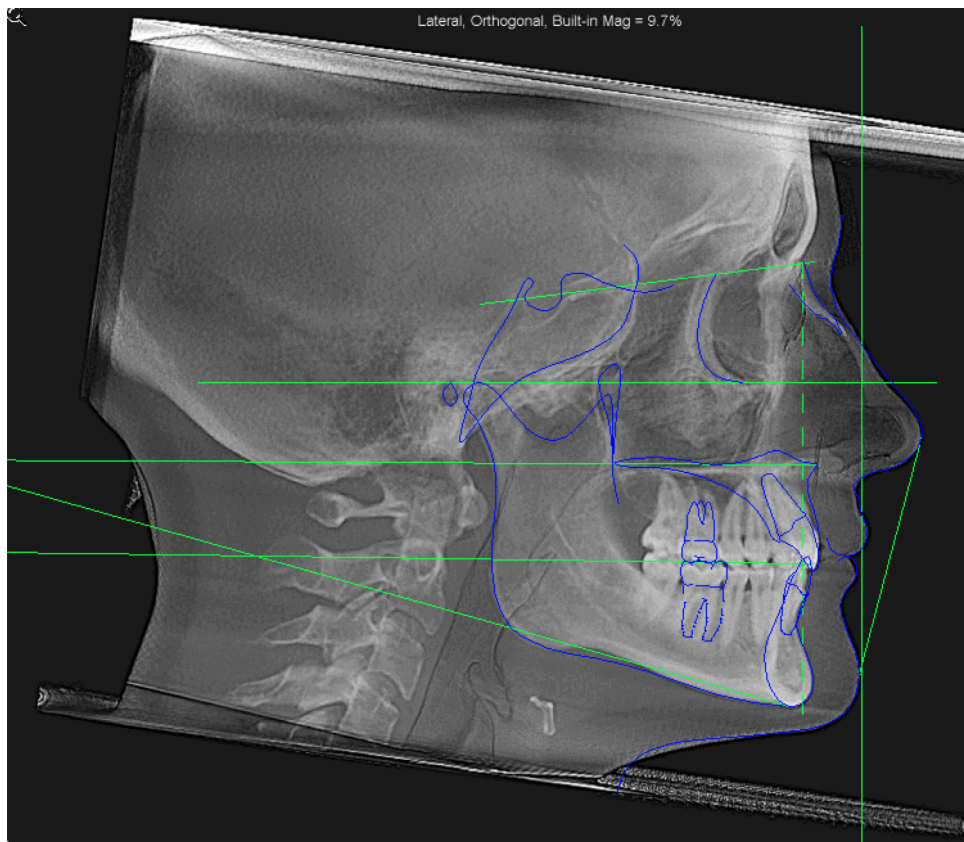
2D lateral cephalogram generated from a 3D CBCT rendering with the head oriented in OHP. Digitized using the Minnesota 2012 analysis in Dolphin 3D software. This cephalogram also shows a generated vertical line unique to the patient, subnasale vertical (SnV), with the head in this orientation to which soft-tissue measurements can be made.
